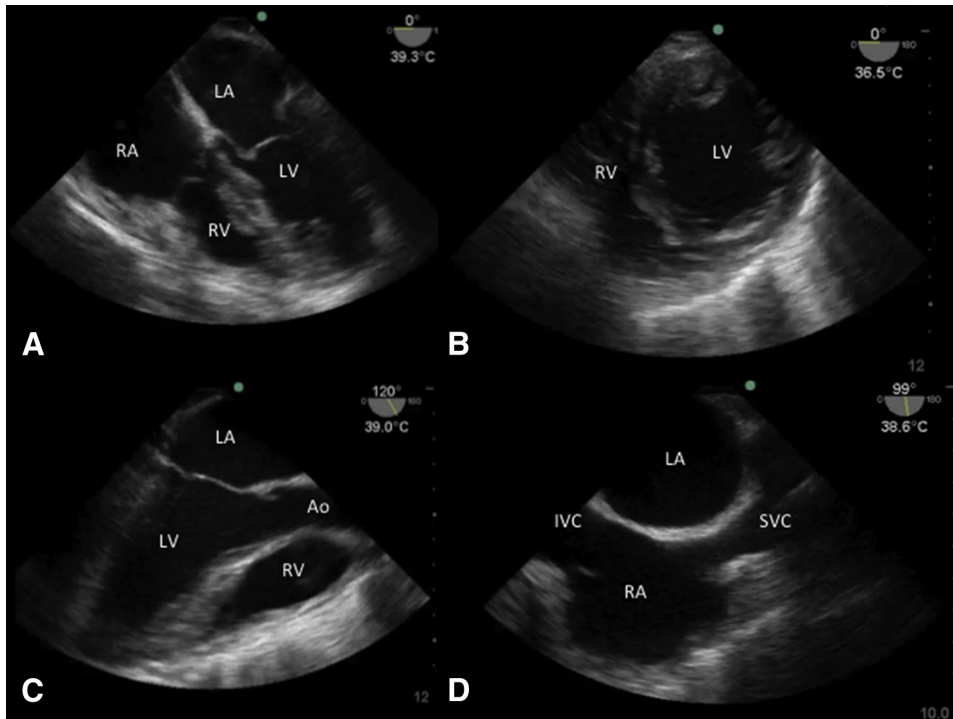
Representative 4 views of our focused emergency department transesophageal echocardiography protocol obtained from a patient with undifferentiated hypotension. (A) mid-esophageal 4 chamber view; (B) transgastric short axis; (C) mid-esophageal long axis; (D) bicaval view. Ao = aorta; IVC = inferior vena cava; LA = left atrium; LV = left ventricle; RA = right atrium; RV = right ventricle; SVC = superior vena cava.
